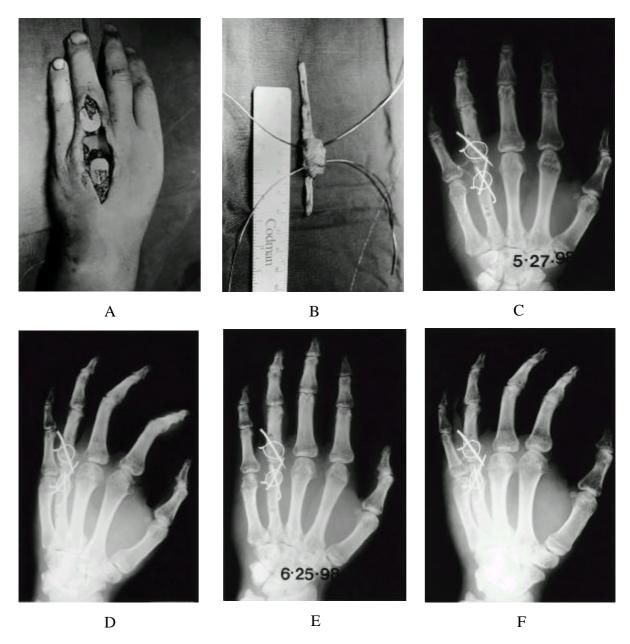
A Extensor tendons and bone were exposed through dorsal incision. B. The third toe PIP joint and extensor tendons were harvested and prepared. C, D. MP joint was transferred and fixed with cerclage wiring and K-wires. E, F. Radiographs of 1 month postoperatively show no arthritic changes.
